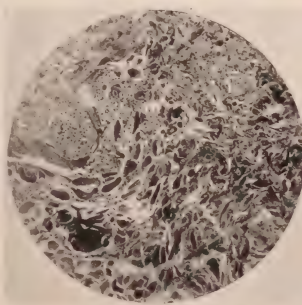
Lymph node invaded by carcinoma metastatic from tonsil, treated by heavy x-ray radiation and removed surgically one month later.
